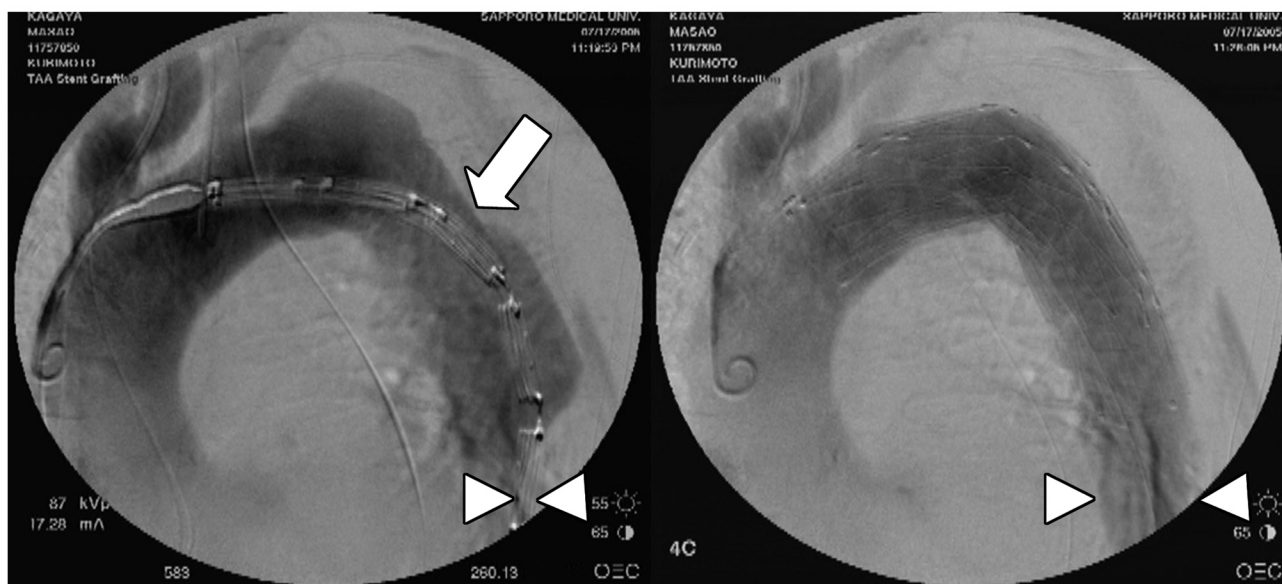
81-year-old man with acute type IIIa aortic dissection complicated with visceral and leg ischemia. The entry site (white arrow) was revealed by intravascular ultrasound (IVUS) before deployment of the stent graft. Critically compressed true lumen of the distal descending thoracic aorta is sufficiently expanded by the entry closure using the stent graft (white arrowheads).
